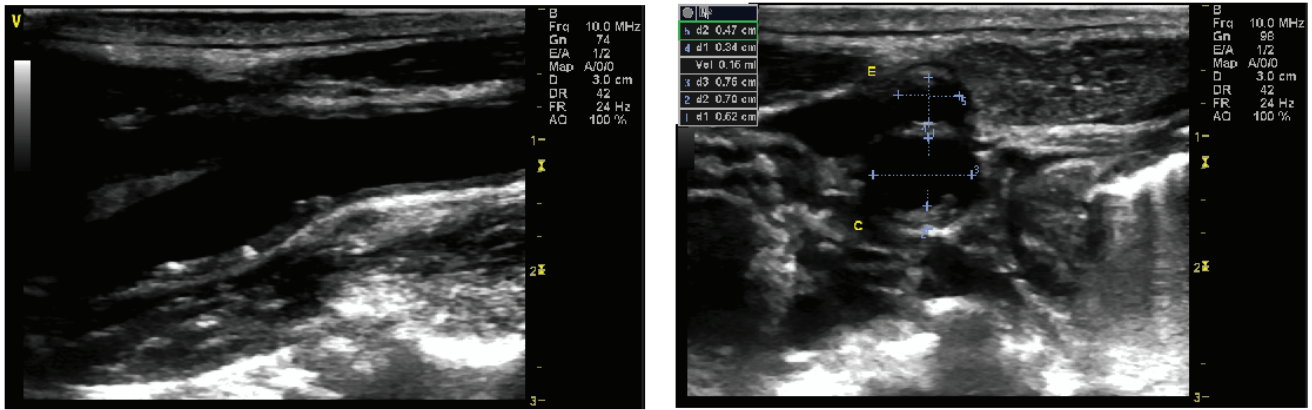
Ultrasound images of the volunteer P1 common carotid artery bifurcation region: longitudinal (left) and cross-sectional (right) images.
